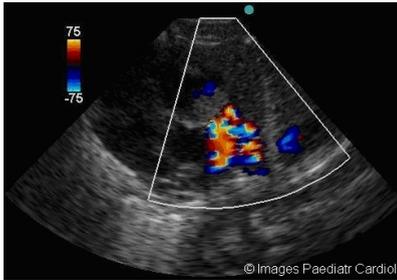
Colour Doppler Of Right Ventricular Outflow Tract
